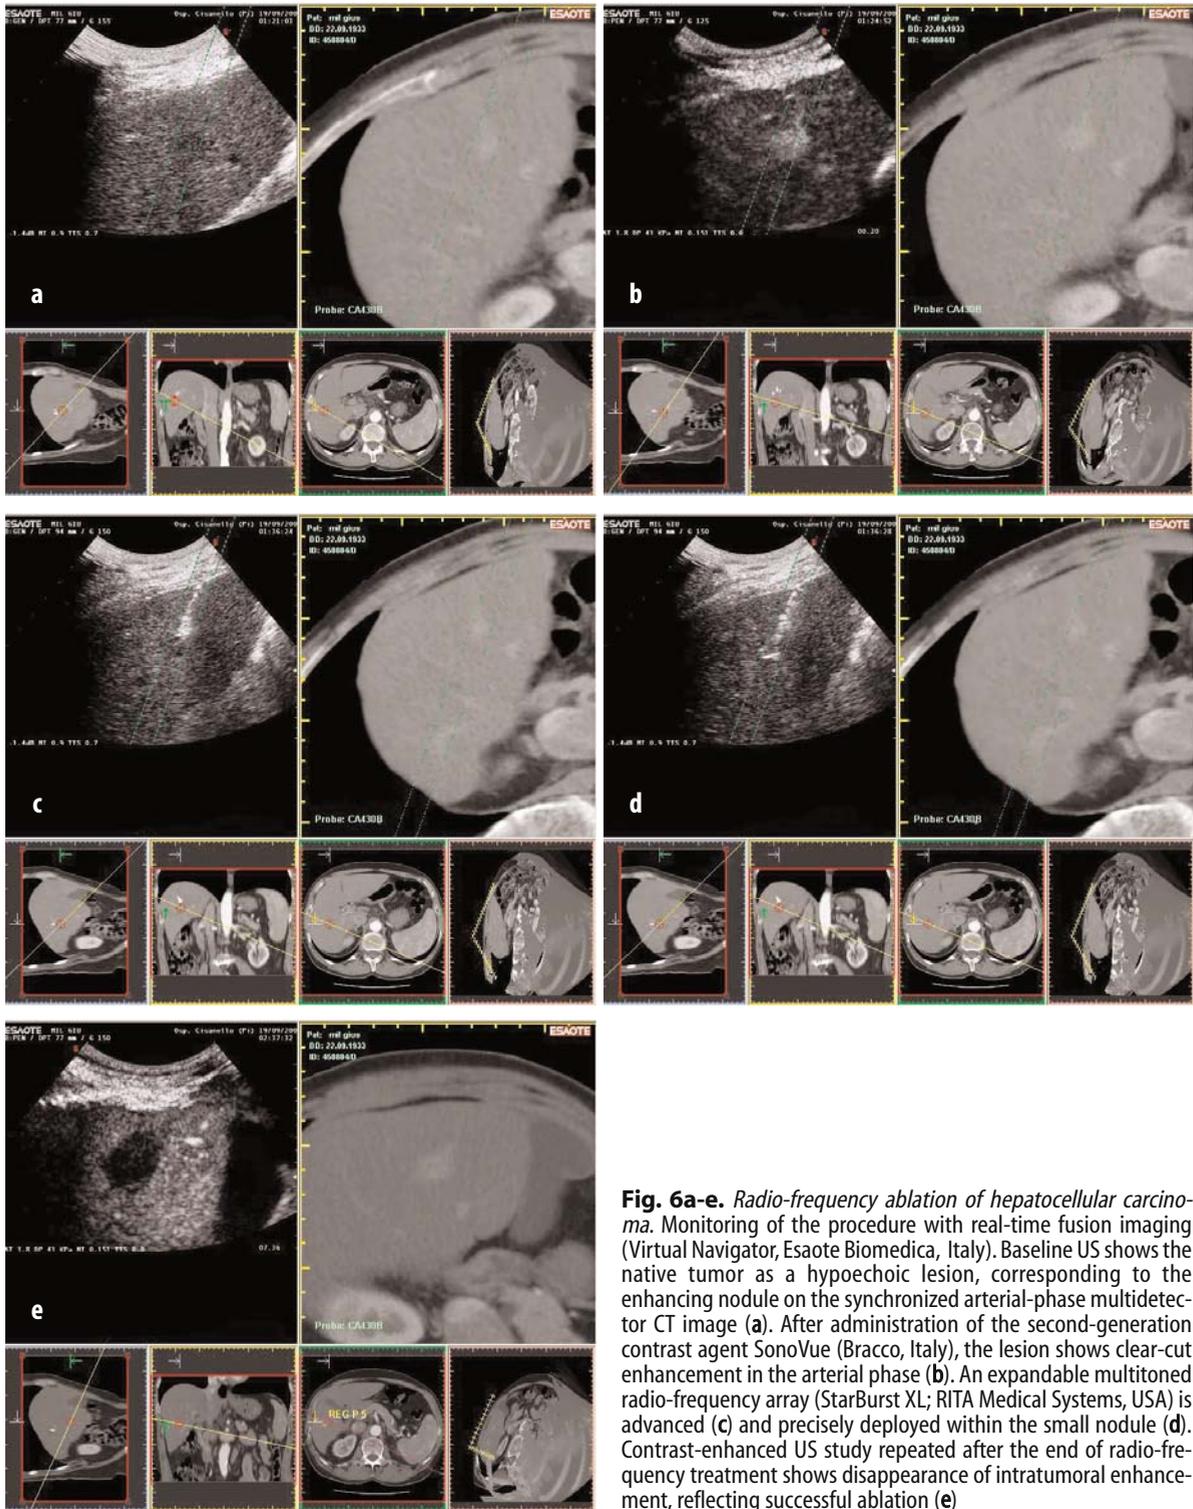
Radio-frequency ablation of hepatocellular carcinoma. Monitoring of the procedure with real-time fusion imaging (Virtual Navigator, Esaote Biomedica, Italy). Baseline US shows the native tumor as a hypoechoic lesion, corresponding to the enhancing nodule on the synchronized arterial-phase multidetector CT image (a). After administration of the second-generation contrast agent SonoVue (Bracco, Italy), the lesion shows clear-cut enhancement in the arterial phase (b). An expandable multitoned radio-frequency array (StarBurst XL; RITA Medical Systems, USA) is advanced (c) and precisely deployed within the small nodule (d). Contrast-enhanced US study repeated after the end of radio-frequency treatment shows disappearance of intratumoral enhancement, reflecting successful ablation (e)
